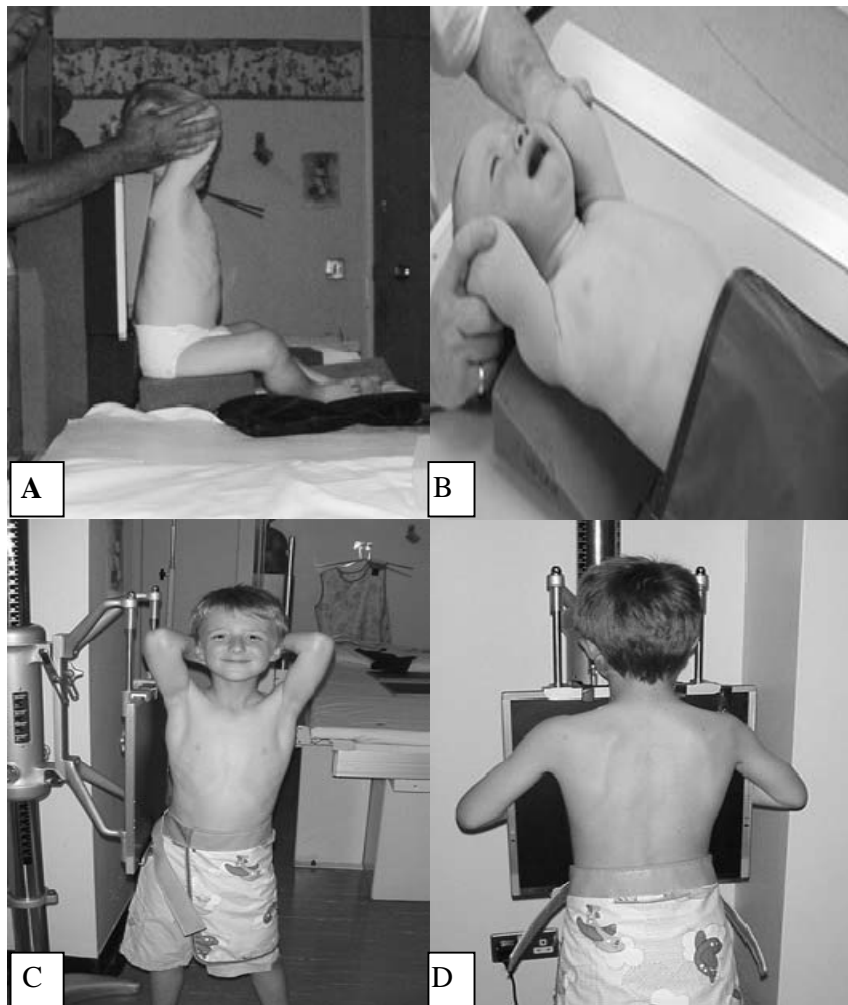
Radiographic procedure on chest. A: Antero-Posterior (erect).B: Antero-Posterior (supine). C: Lateral projection. D: Postero-Anterior projection.
